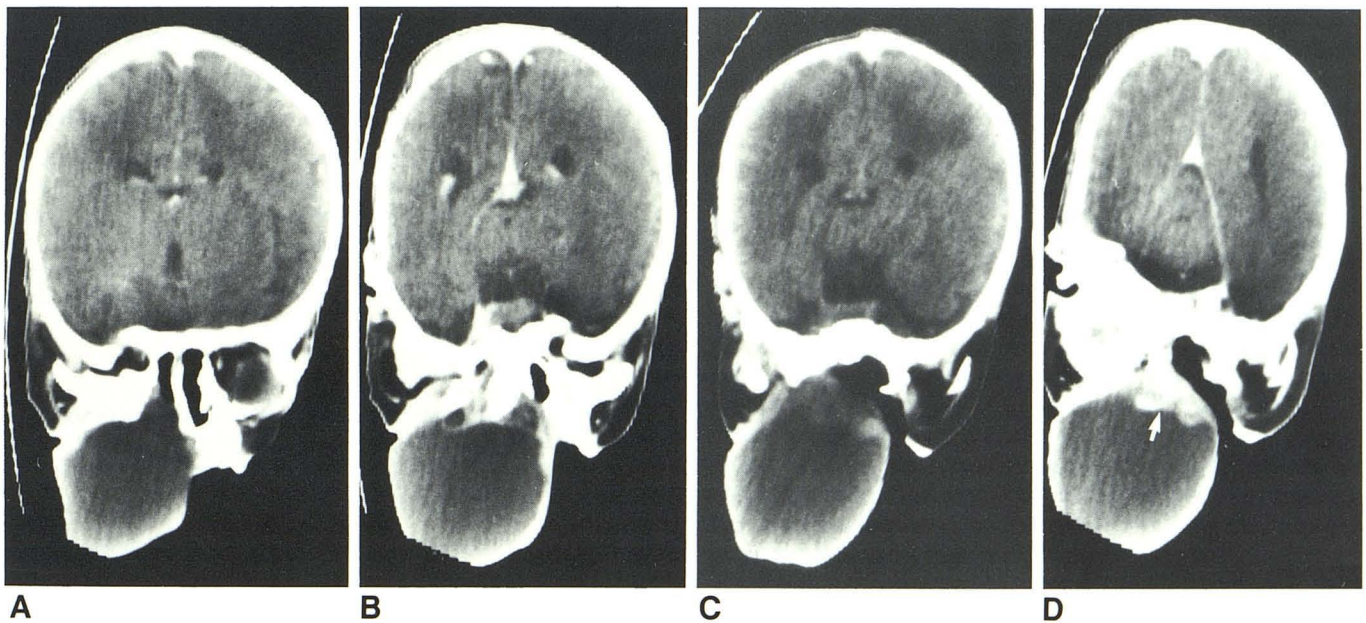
Near coronal CT. Images are displayed from anterior to posterior.
